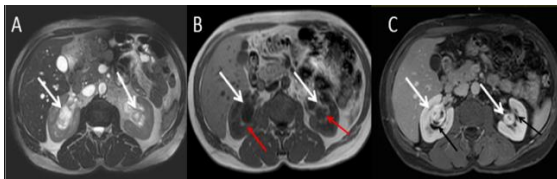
Axial T2 Weighted Magnetic Resonance Imaging (MRI) Showing 2 Masses Separated from the Renal Parenchyma by a Collecting System (Figure B and C, black & red arrows). Furthermore:
